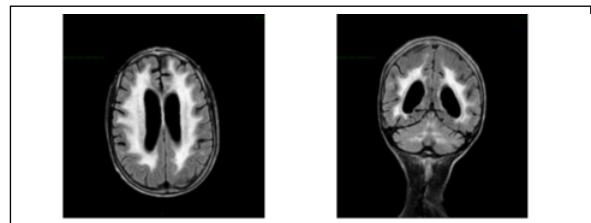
C: Axial and coronal FLAIR MRI.
